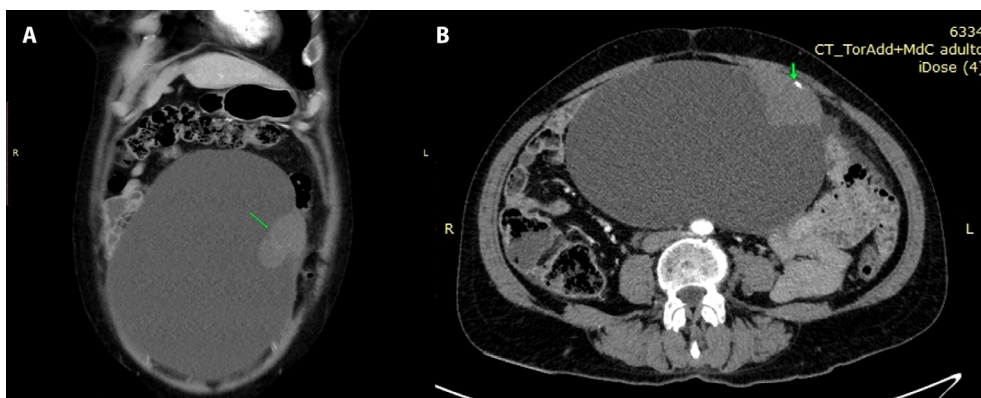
A) Solid component is noted in the left upper portion of the left ovarian cyst on coronal CT. B) Speck of calcification is noted in the periphery of the lesion.
